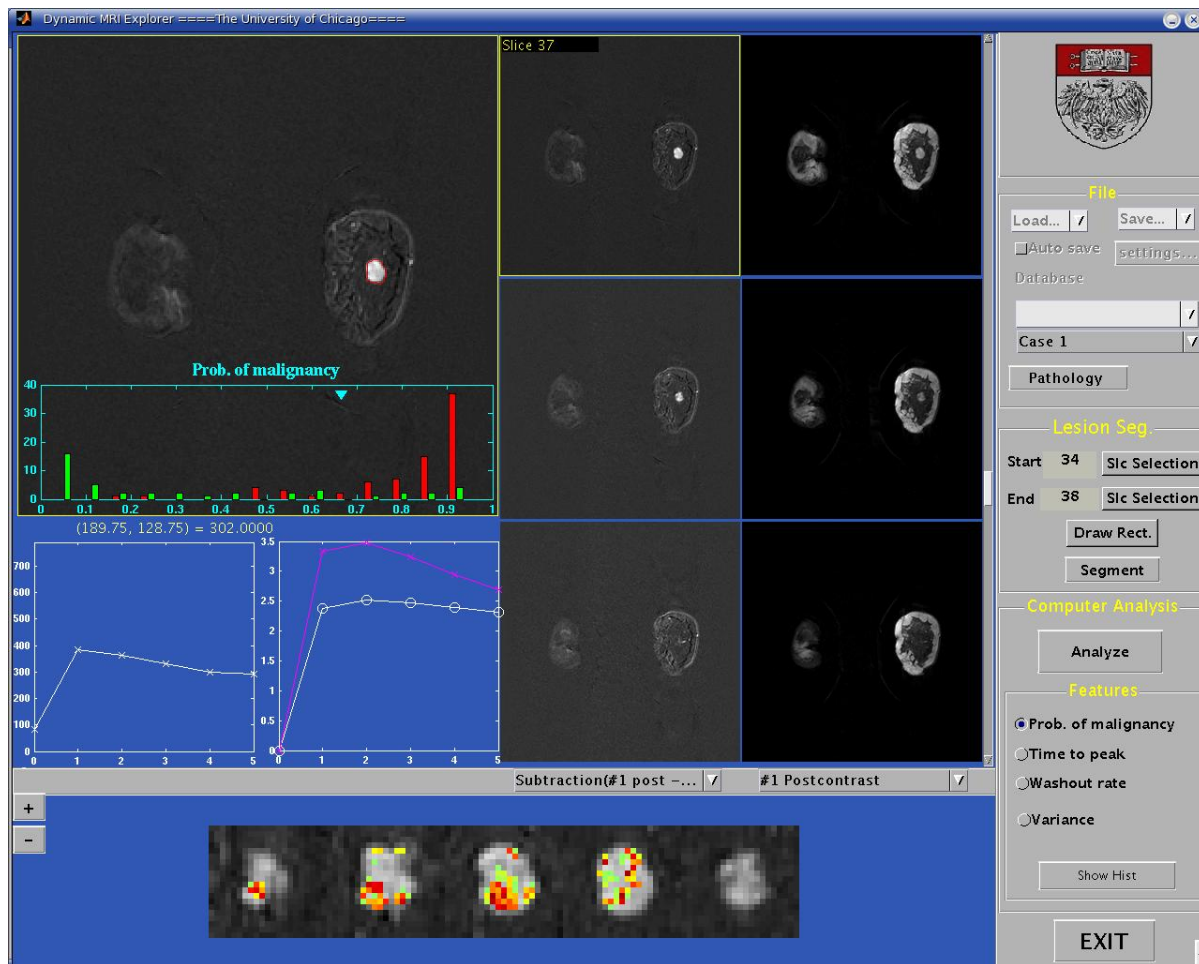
Graphical user interface (GUI) we developed for computerized image analysis in breast MRI
